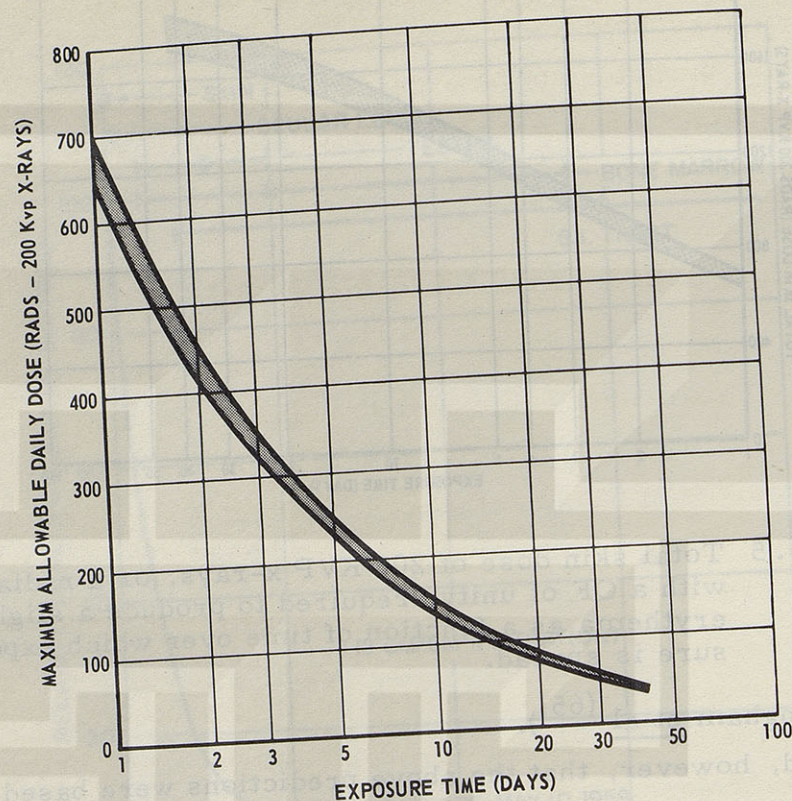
Maximum daily dose of 200 KVP x-rays, or a radiation with a QF of unity that can be given and not exceed the slight erythema threshold as a function of the period over which the exposure is protracted.
